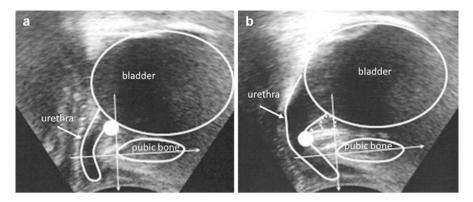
Ultrasound scan, bladder neck mobility. Perineal ultrasound for evaluation of bladder neck mobility. Bladder neck at rest (a) and with Valsalva (b), point indicates the bladder neck, arrow as vector for bladder neck mobility
